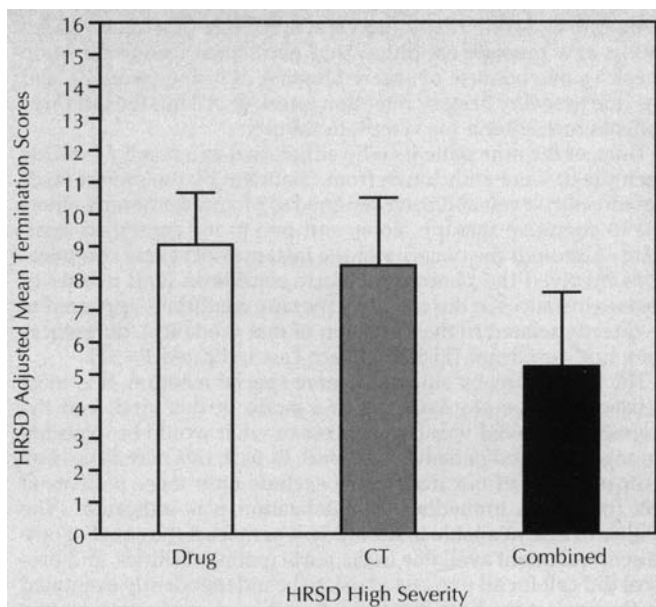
Posttreatment depression by condition among high-severity treatment completers. Hamilton Rating Scale for Depression (HRSD) scores are least-square (+SE) treatment scores from a one-way analysis of covariance with pretreatment severity on the HRSD as the covariate. Data are for treatment completers scoring 20 or above at intake on the HRSD (the HRSD criterion used to define high severity in the National Institute of Mental Health Treatment of Depression Collaborative Research Program⁴). Drug indicates the pooled pharmacotherapy-only conditions (n=25); CT, cognitive therapy (n=15); and Combined, the combined condition (n=12).
